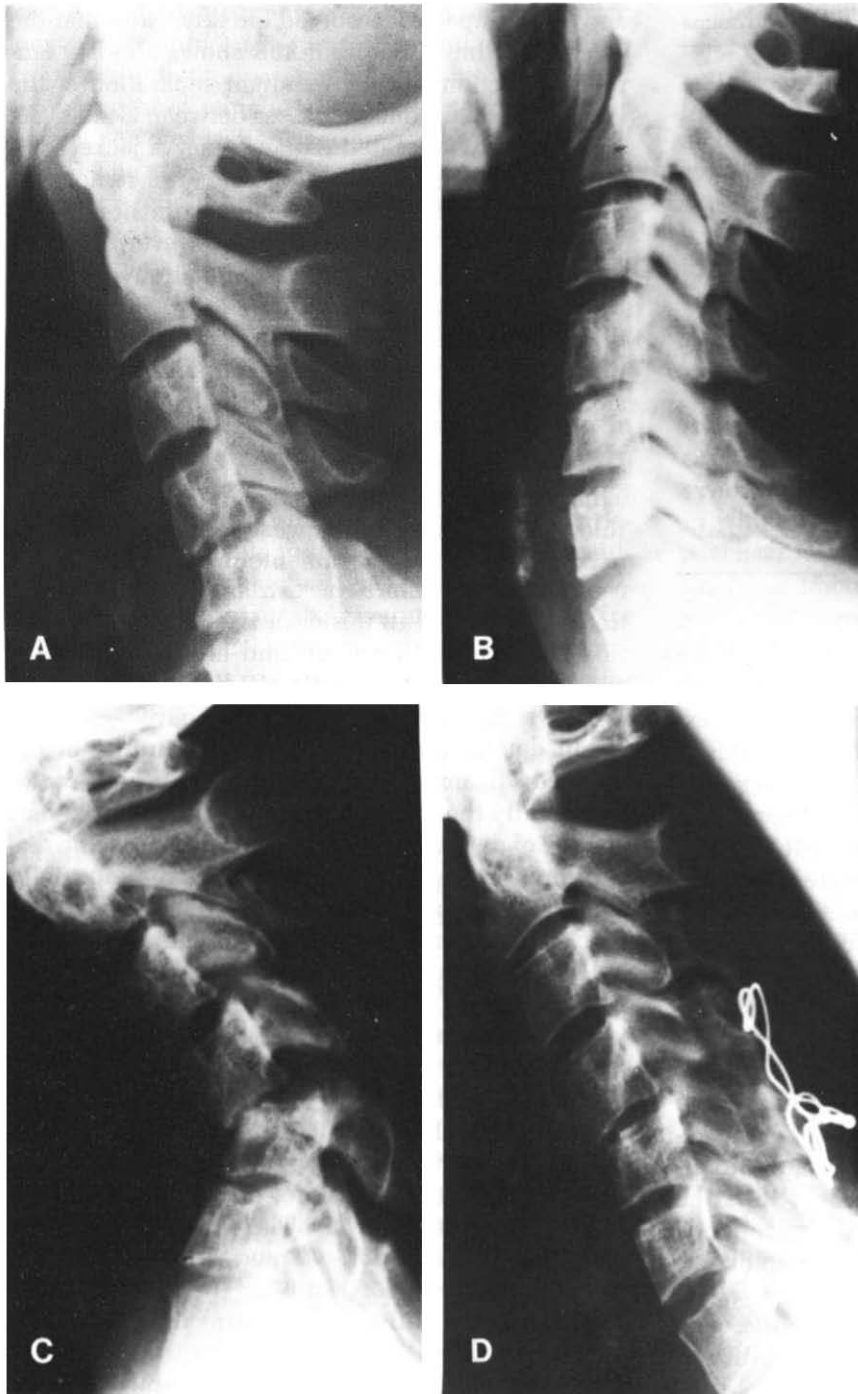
Radiographs of a flexion injury in a 19-year-old with transient spinal cord symptoms. (See p. 305 for a case report.) Knowing the nature of the injury, could the re-subluxation shown in C have been predicted from radiographs A (taken on admission) and B (taken after 3 months of treatment)? This clinical picture and radiographic presentation should be learned so that the diagnosis can be made or suspected when the patient is first seen. (A, B, and D courtesy of T. McSweeney and W. Park; C from Webb, J. K., Broughton, R. B. K., McSweeney, T., and Park, W. M.: Hidden flexion injury of the cervical spine. *J. Bone Joint Surg.*, 58B:322, 1976.)
